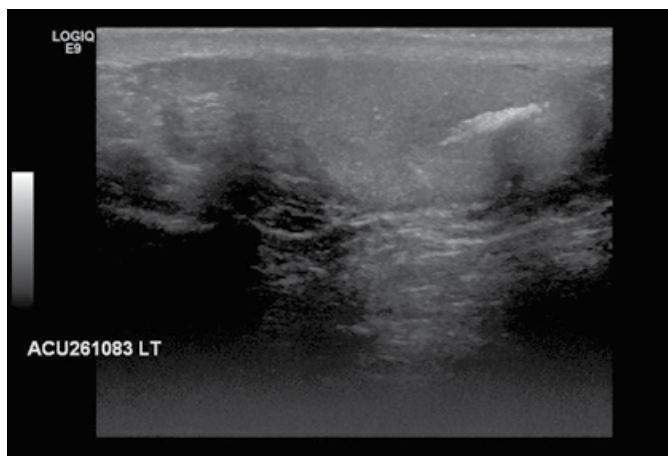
Ultrasound scan left testis, 12 mm coarse calcification and hypoechoic areas, (note absence of previous solid lesion).
